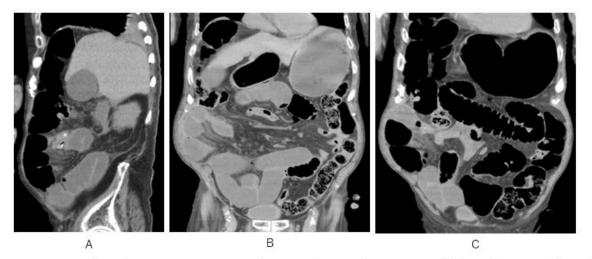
Two days later, mesenteric edema is depicted on sagittal (A) and coronal (B, C) CT. Note that mesenteric edema concentrate to one point where no beak sign of bowels are absent.
